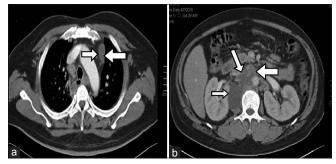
(a) A computed tomography scan of the chest showing necrotic mediastinal lymph node and (b) a computed tomography scan of the abdomen showing large necrotic portocaval lymph node with liquefaction
